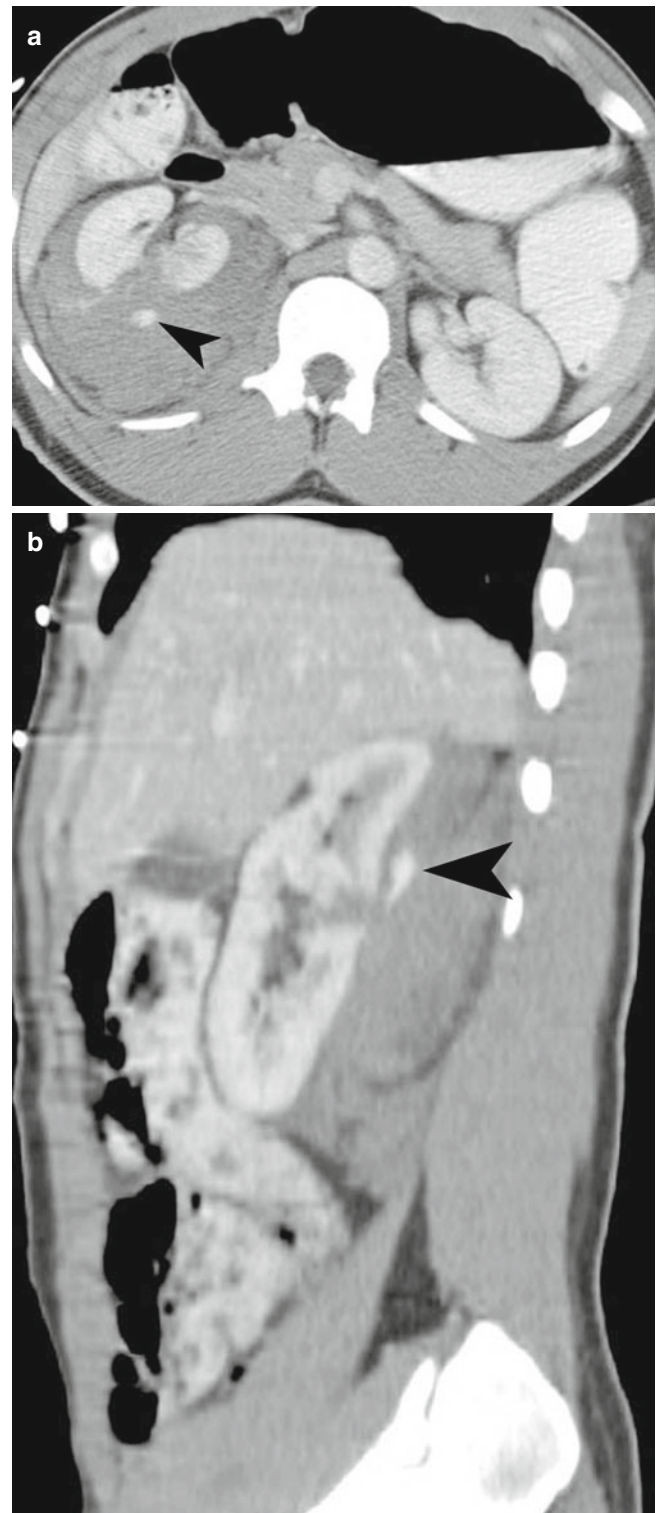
Renal injury, CECT. (a and b) Axial and sagittal contrast-enhanced CT demonstrate right renal laceration with extravasation of contrast (*arrowhead*) into a perinephric hematoma
